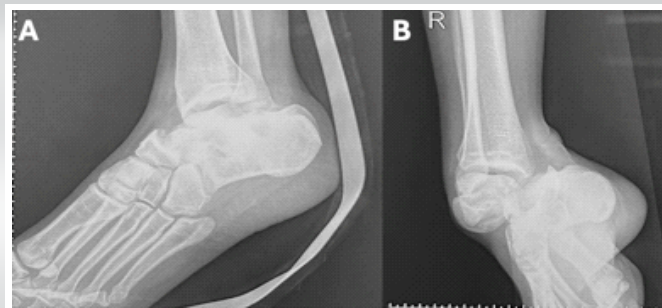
Pre-operative radiographs showing medial subtalar joint dislocation with talonavicular joint dislocation.
